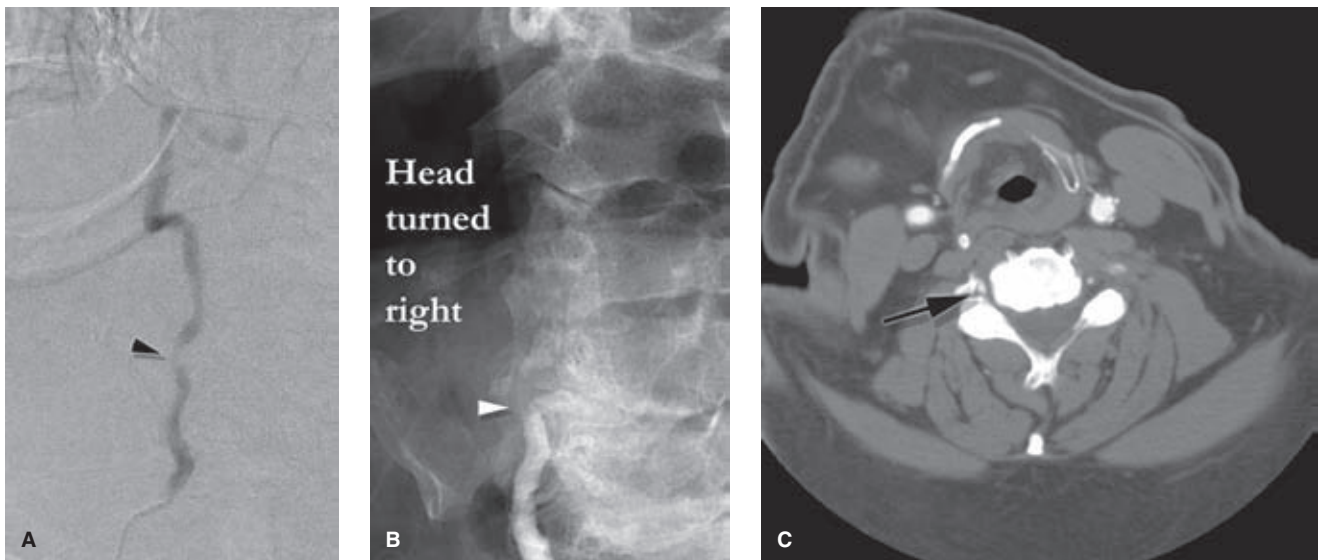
(A–C) Bow hunter's phenomenon II. This patient presented with a similar clinical appearance as the patient described in Figure 28-1. A roadmap mask (A) taken in a state of rotation not quite at the level expected to induce symptoms shows compression of the lumen of the midright vertebral artery (arrowhead in A). With more neck rotation toward the right, there is complete occlusion of the vessel (arrowhead in B) associated with diffuse mild atherosclerotic disease of the vessel and prominent hypertrophic degenerative disease of the adjacent uncovertebral joints of the cervical spine. An image from his CTA examination (taken in a state of mild rotation to the right, the patient was not willing to induce his symptoms for the sustained period necessary for the CTA examination) shows the distortion and compression of the right vertebral artery (arrow in C) at the level of the C4 to C5 disc.
